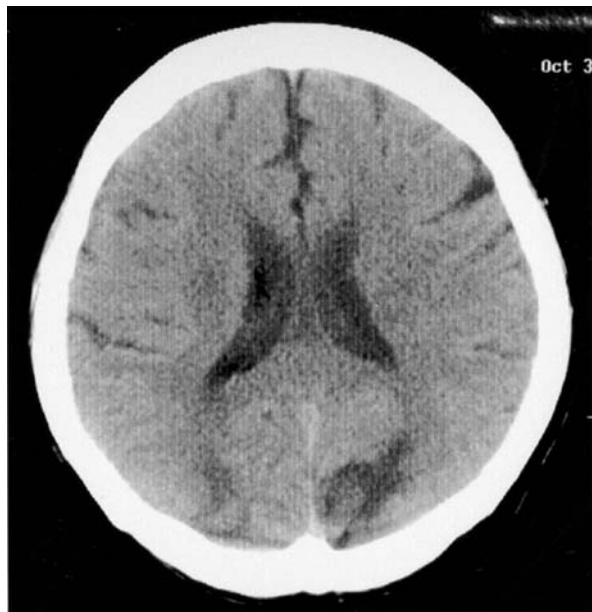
A head CT scan on October 31, 2000. Low-density areas were observed in bilateral occipital lobes, predominantly on the left-hand side
